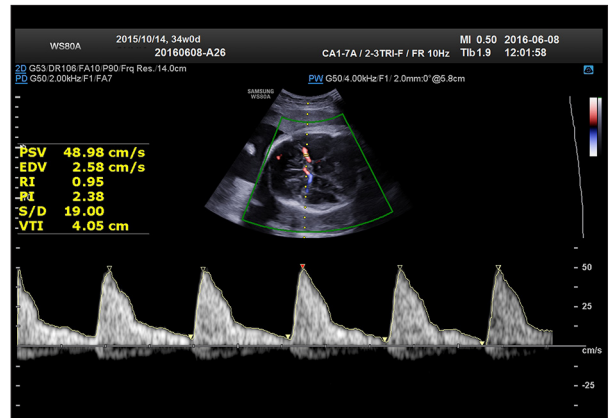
Ultrasound Doppler spectrum of fetal MCA in the placenta previa group.
